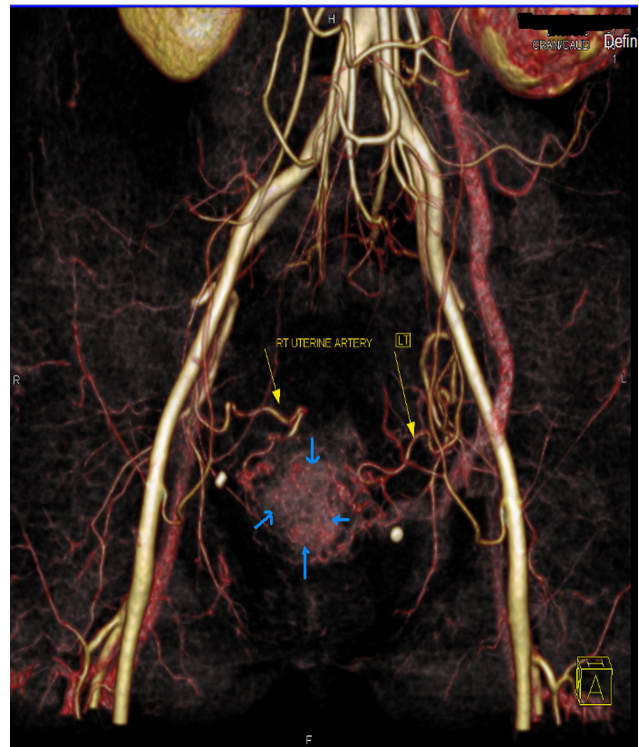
CT angiography showing uterine mass (marked with blue arrow) and uterine arteries (marked by yellow arrows)
